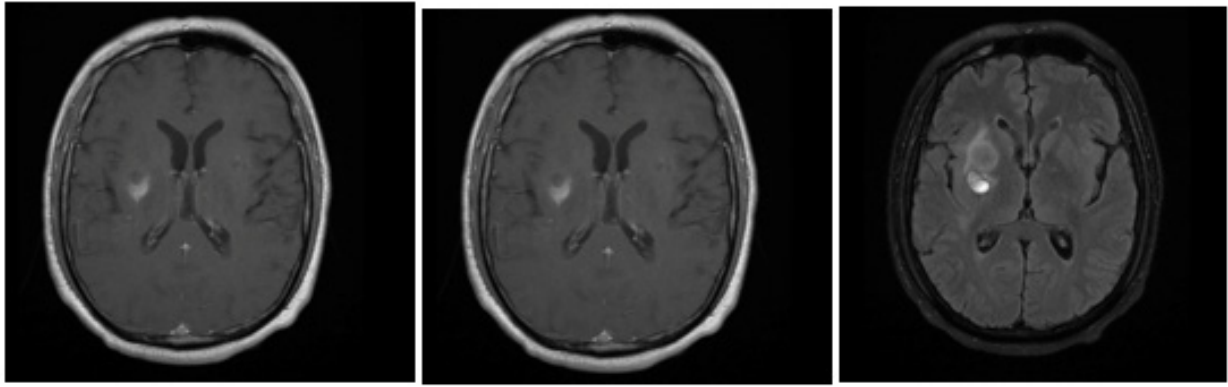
MRI: Significant imaging improvement compatible with response to established treatments persisting smaller with reduction of the vasogenic edema reaction.
